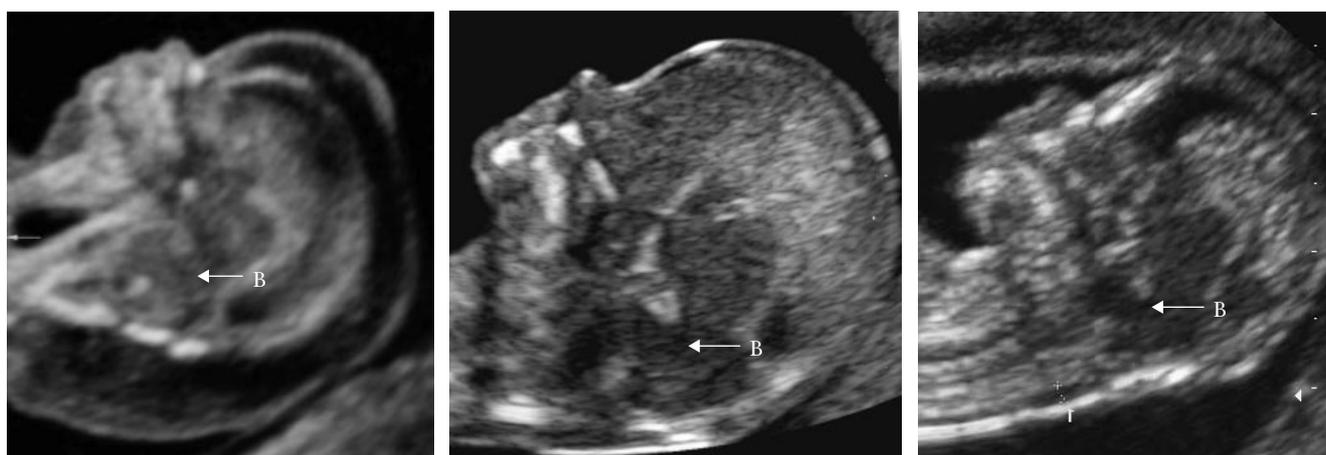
Ultrasound images in the mid-sagittal plane of the fetal faces of the three additional cases of spina bifida. The arrows point to the brain stem with absence of the fourth ventricle (compare with the normal case in Figure 1).
